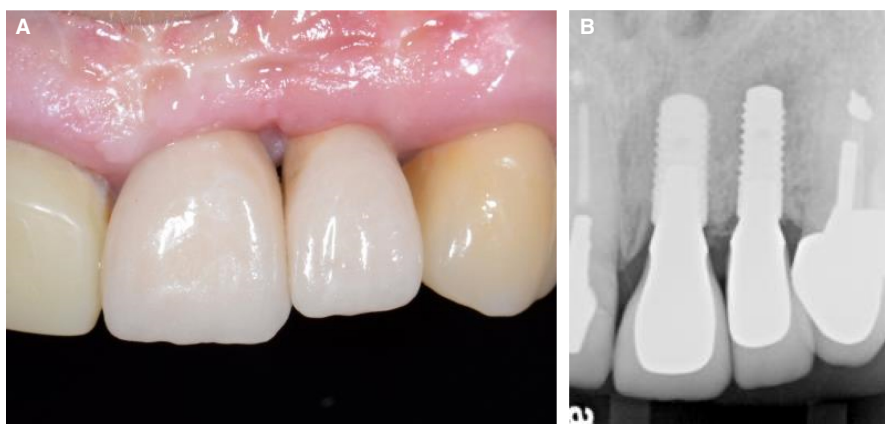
A, The interimplant papilla has failed to form because of the proximity of the two implants in the maxillary left central and lateral incisor sites. B, The corresponding radiograph shows that the two implants with an internal conical abutment connection design have been placed about 2 mm apart at the shoulder. Despite the peak of bone present between the two implants, the interimplant papilla failed to form a proper morphology
